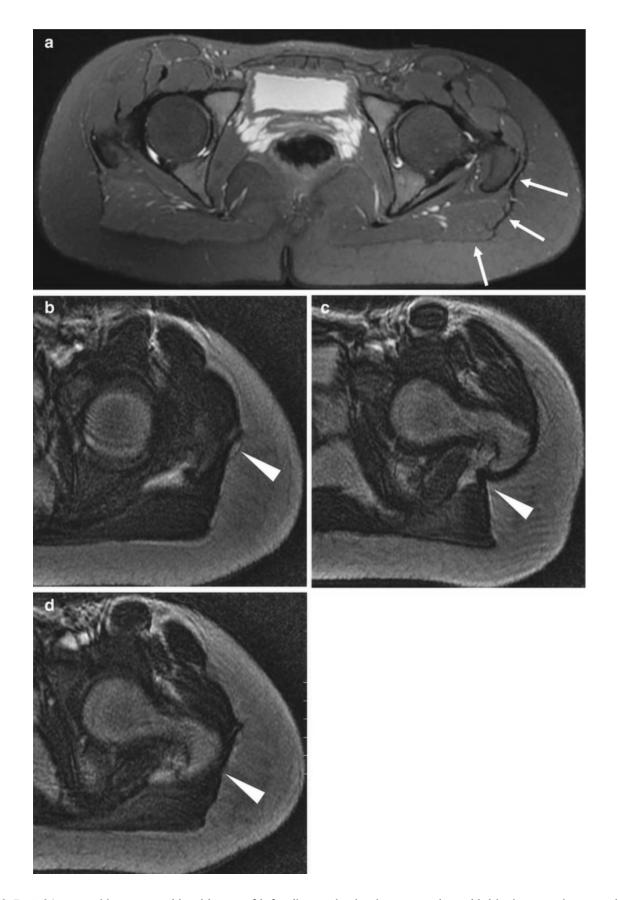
A 21-year-old woman with a history of infantile cerebral palsy presenting with blockage and a snapping sensation of the left hip. (a) Static fat-suppressed axial T2-weighted MRI at the level of the greater trochanter shows a normal aspect of the gluteus maximus (GM) muscle and superficial insertion to the iliotibial band (ITB, arrows). (b—
